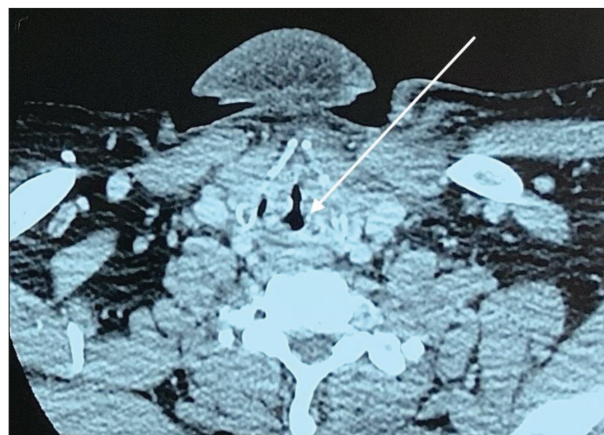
CT image of the massive edema of the left aryepiglottic fold with reduced breathing space
